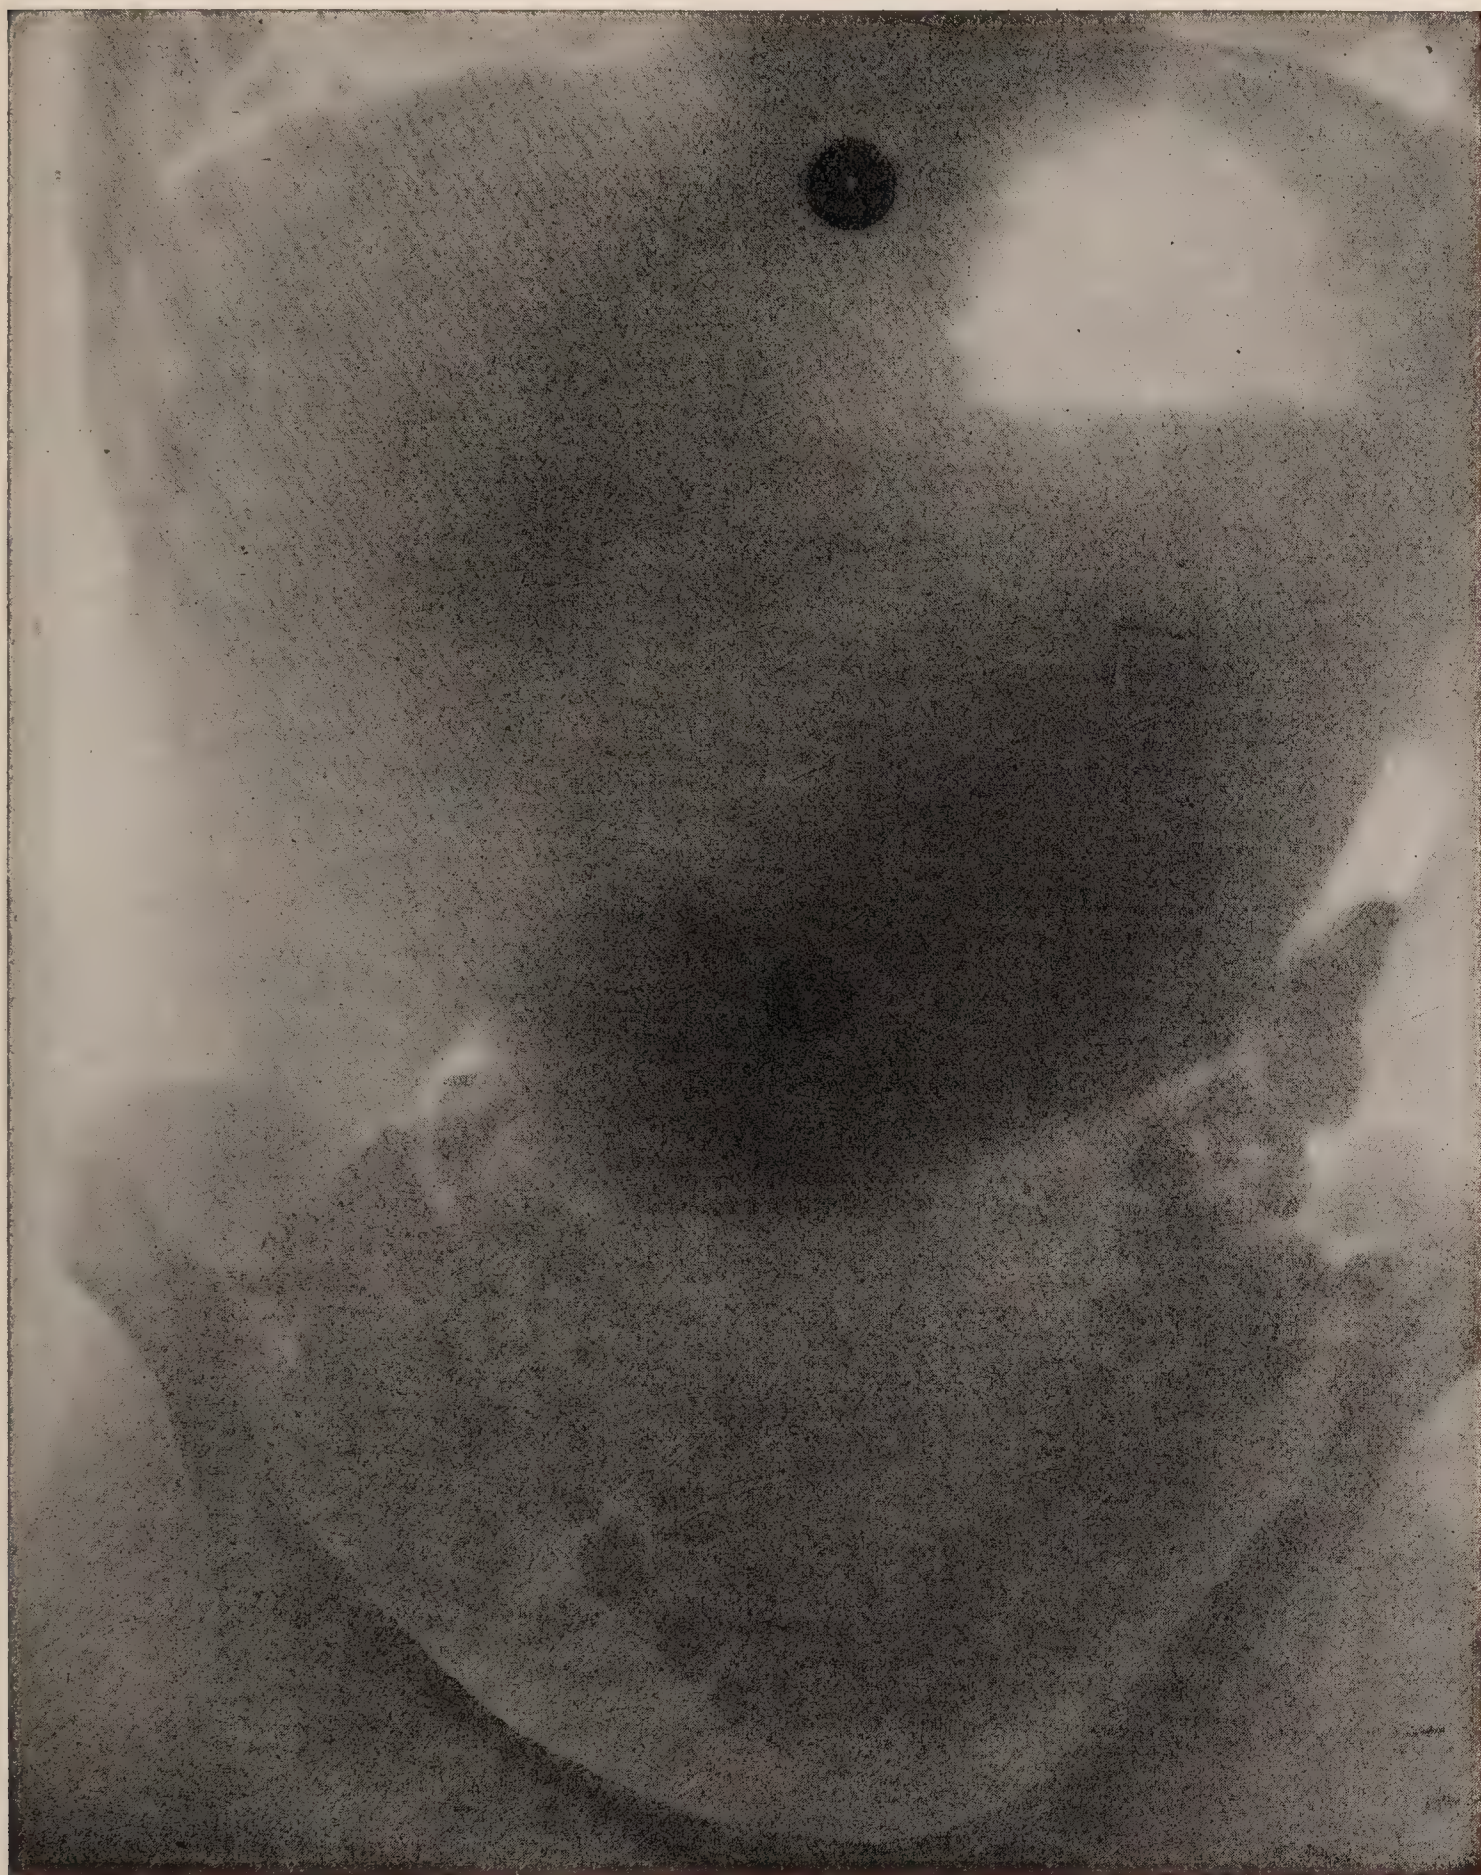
Roentgenogram of enteroptosis (Pfahler).
